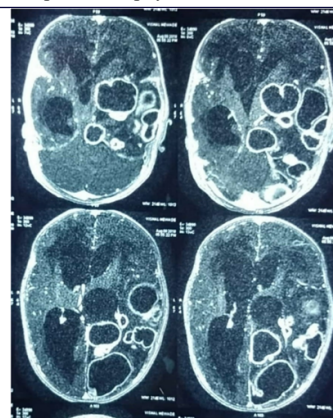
MRI Brain showing encapsulated multiple brain abscesses with midline shift
